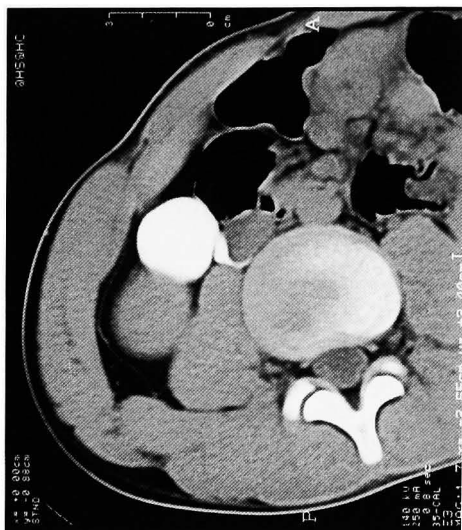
Computed tomography during excretory urography shows the existence of a retrocaval ureter.
